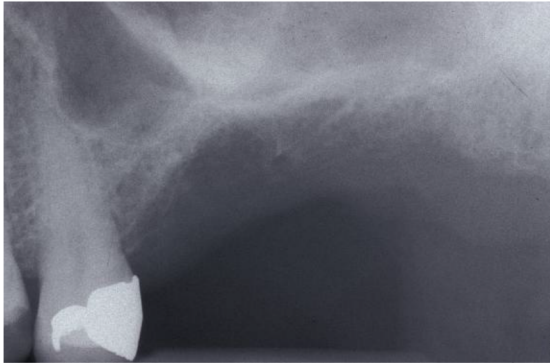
The distance between the ridge crest and the floor of the sinus is measured on a preoperative periapical radiograph.
